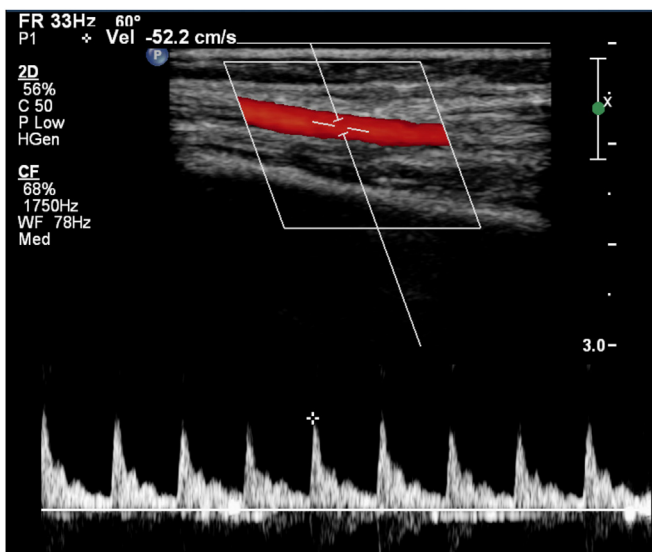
Follow-up ultrasound showing good flow through the brachial artery at the level of the mid-humerus.
